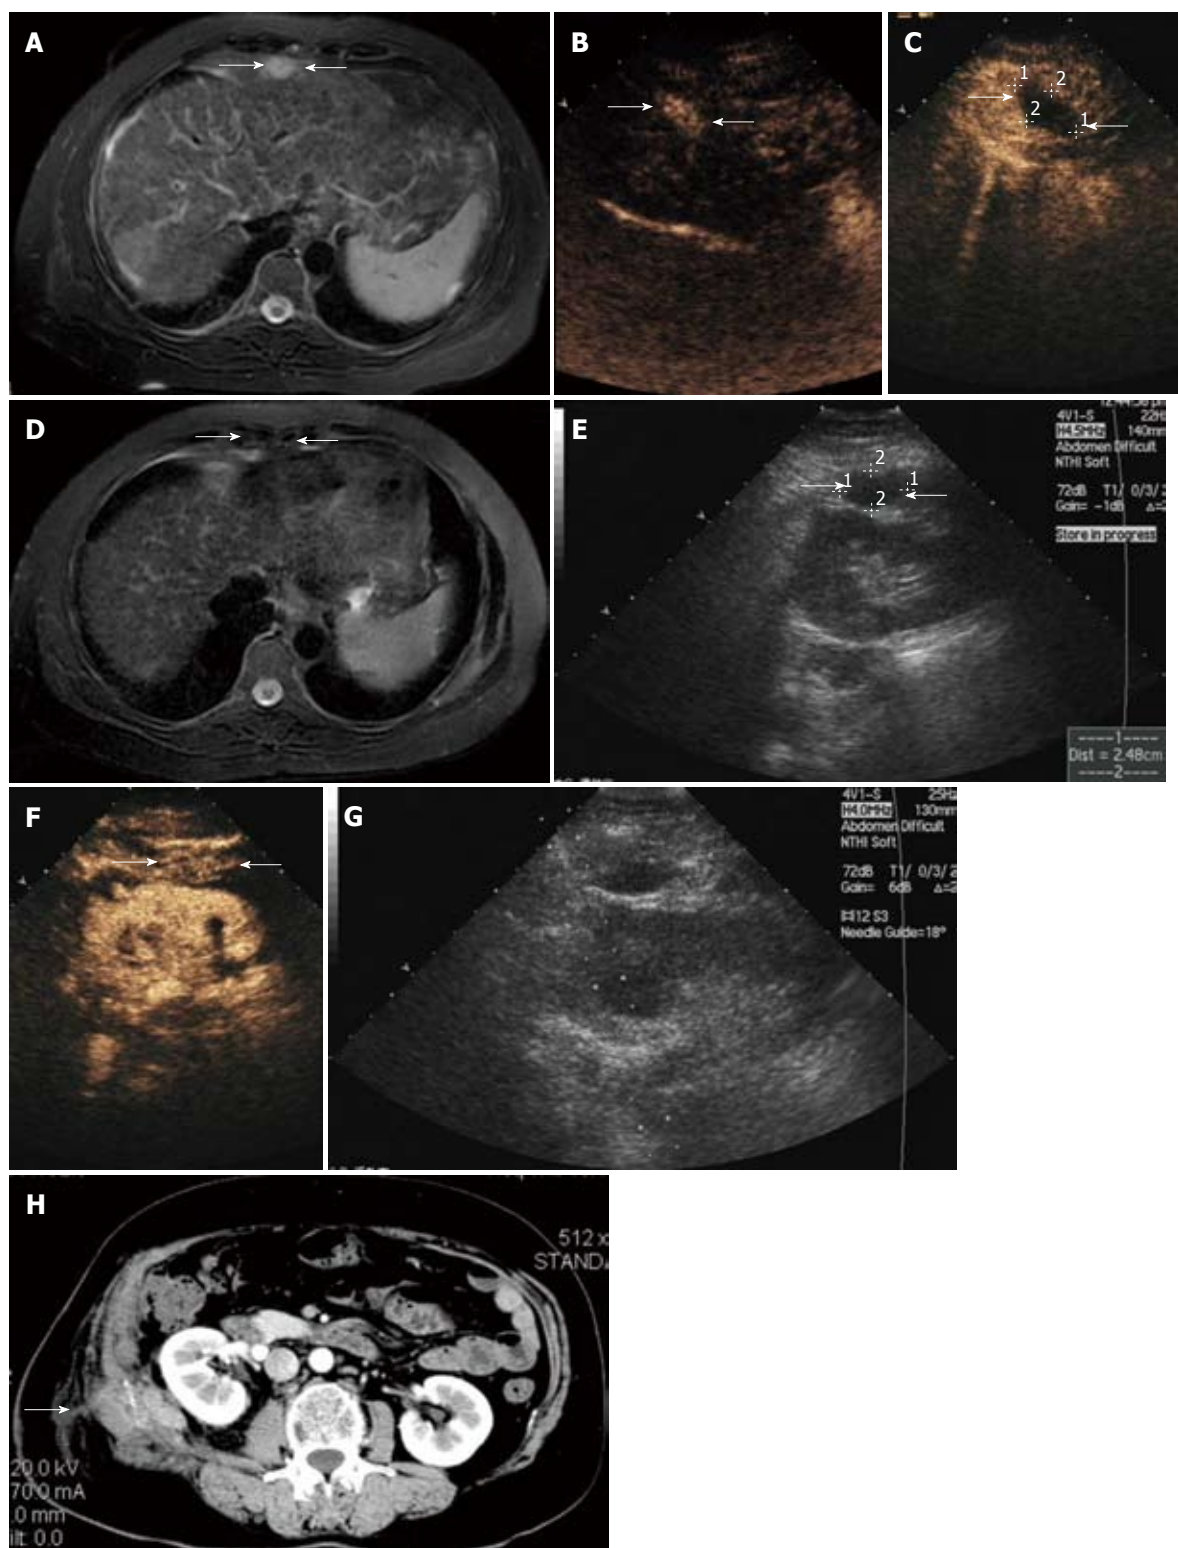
Ultrasound findings in a 56-year-old woman with abdominal wall tumor metastasized from liver and adrenal gland cancer. A: Contrast-enhanced magnetic resonance imaging (MRI) scan shows a lesion with hyperenhancement in T2-weighted images in the abdominal wall (arrow); B: Arterial phase in contrast-enhanced ultrasound (CEUS) shows hyperenhancement within the lesions (arrow); C: CEUS scan obtained 3 d after microwave (MW) ablation shows a hypoechoic area with no enhancement, suggestive of complete necrosis (arrow); D: Contrast-enhanced MRI scan shows a lesion with hypoenhancement in T2-weighted phase MR image obtained 1 mo after MW ablation revealing complete ablation. Contrast-enhanced MRI scan shows a lesion with hypoenhancement in T2-weighted images in the abdominal wall (arrow); E: Sonogram obtained before MW ablation shows hypoechoic nodule of 2.48 cm in maximum diameter in the abdominal wall (arrow); F: Arterial phase in CEUS shows hyperenhancement within the lesions (arrow); G: Sonogram obtained during MW ablation shows one antenna being inserted into the nodule; H: Abdominal wall edema occurred at the right lumbar in the arterial phase of contrast-enhanced CT (arrow).
